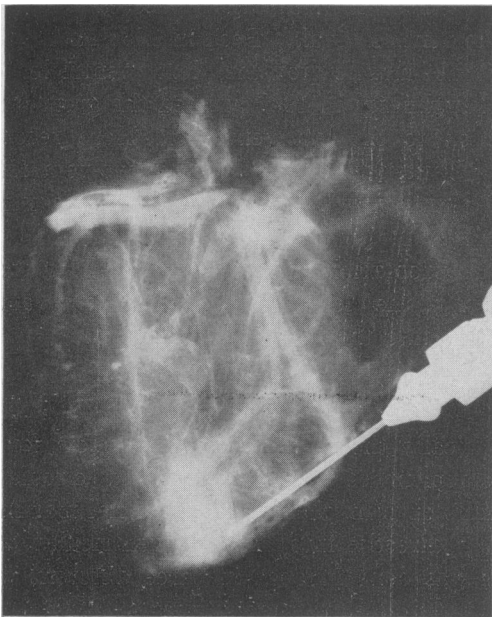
X-ray showing radio-opaque solution filling the left coronary system after injection into the transplanted left internal mammary artery.
